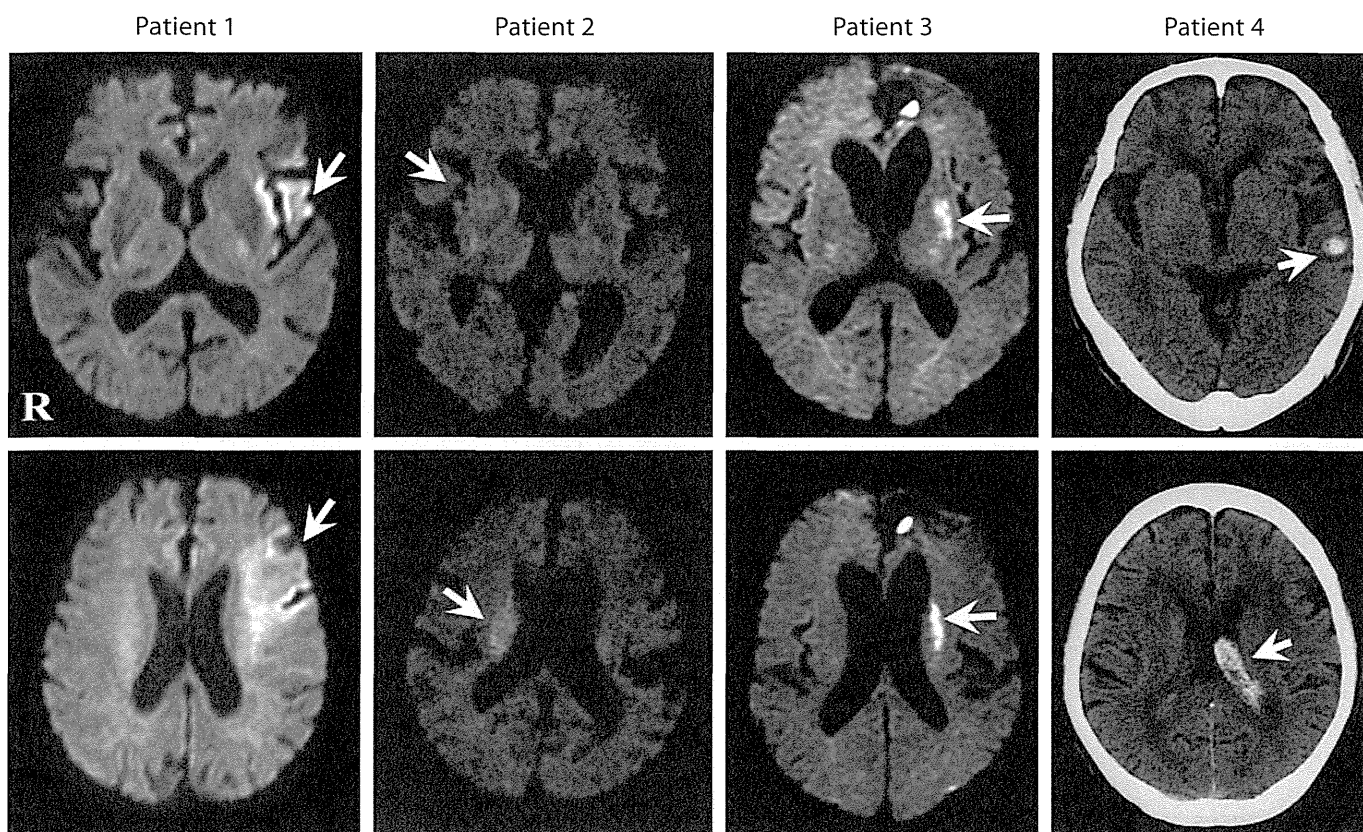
DWI just before IV rt-PA therapy in patients 1–3, and CT on the day of thrombolysis in patient 4. Arrows show early ischemic changes or ectopic hemorrhage.
